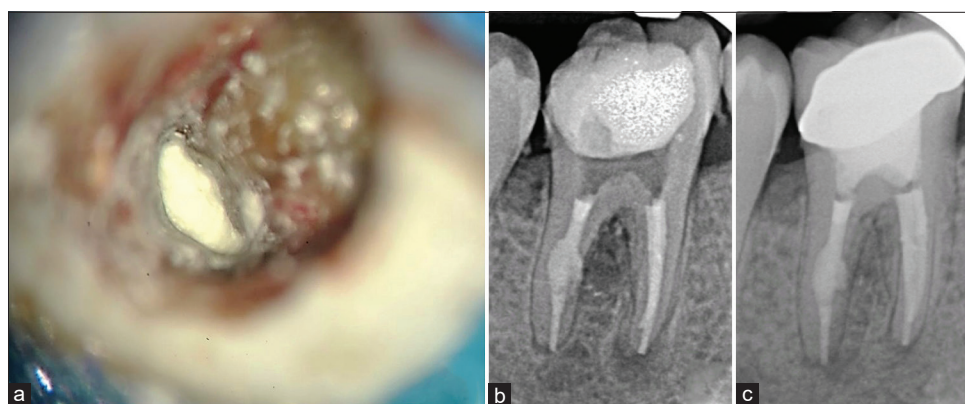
(a) Mineral trioxide aggregate placed and the perforation site sealed. (b) Radiograph showing complete obturation along with sealed perforation. (c) One year recall showing significant healing of the lateral lesion along with the sealed perforating internal resorption defect
